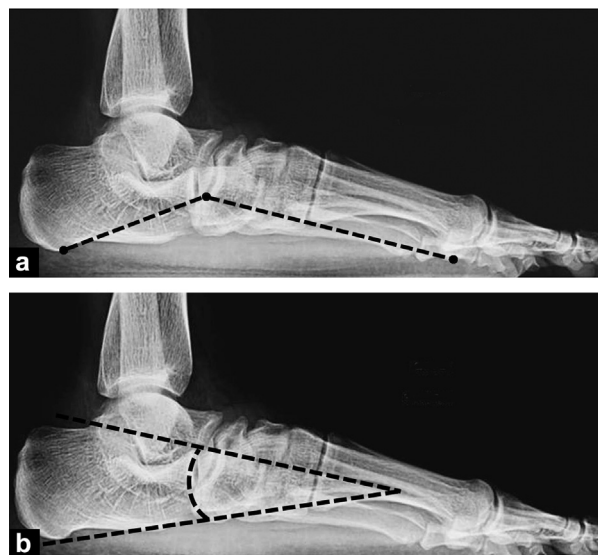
Measurement of Djian-Annonier and talocalcaneal divergence. A. Measurement of the Djian-Annonier angle in weight-bearing lateral radiograph of the foot. The angle is measured between the lowest point of the calcaneal tuberosity, the lowest point of the talonavicular joint and the lowest point of the medial sesamoid of the hallux. Normal values range from 120° to 130°. The Djian-Annonier angle is decreased in case of a flat foot. B. Measurement of talocalcaneal divergence in a weight-bearing lateral radiograph of the foot. Divergence corresponds to the angle formed by the major axis of the calcaneus and the major axis of the talus. Normal values ranged between 15° and 25°. Talocalcaneal divergence is increased in case of a flat foot.
